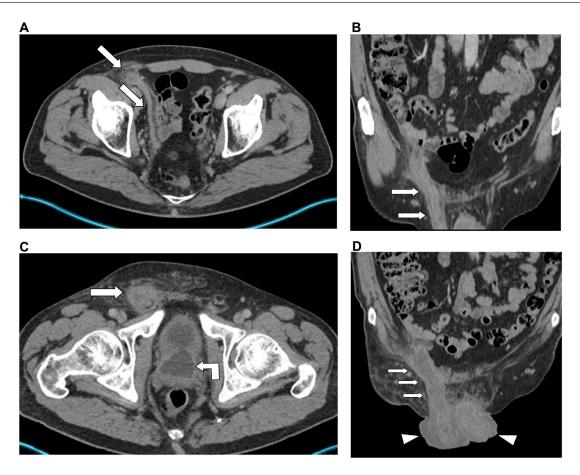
Initial CT portovenous phase axial (A) and coronal (B) slices show a thickened oedematous right vas deferens (white arrows) with peripheral hyperenhancement with central hypodensity and surrounding fat stranding. Follow-up CT 6 days later showed axial (C) and coronal (D) slices with the worsening appearance of the right-sided acute vasitis (white arrows) and bilateral hydrocele (white arrowheads) with a collection at the site of the prostatic bed (bent arrow).
